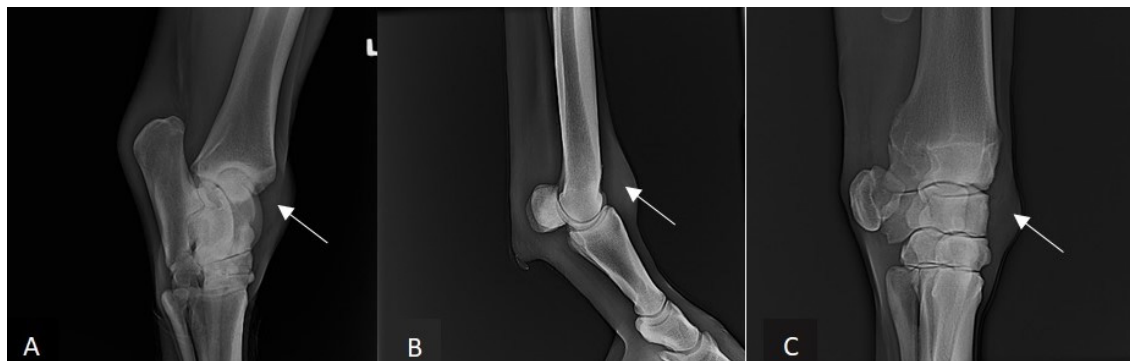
Radiographs of different cases; A. Synovitis of the tarsocrural joint in a 4-year-old English Thoroughbred. B. Synovitis of the metacarpophalangeal joint in a 4-year-old English Thoroughbred, C. Synovitis of the carpal joint in a 3-year-old Arabian Thoroughbred. White arrow: Tension and swelling in the joint capsule with the developing effusion.
